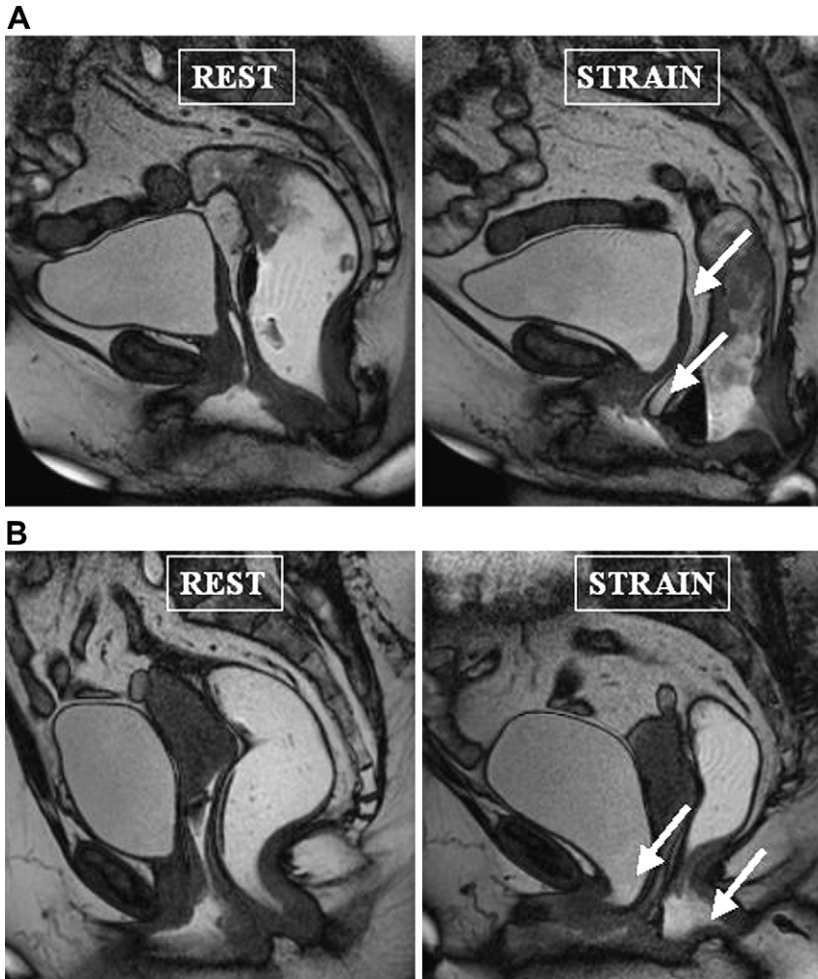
Dynamic MRI defecography. (A) Sagittal view at the beginning (*left*) and at the end (*right*) of the evacuation showing the progressive appearance of an elythrocele (peritoneal pouch into the rectovaginal space) (*arrows*). (B) Sagittal view before (*left*) and after (*right*) the evacuation showing the association of urinary bladder and rectal prolapse (*arrows*).
